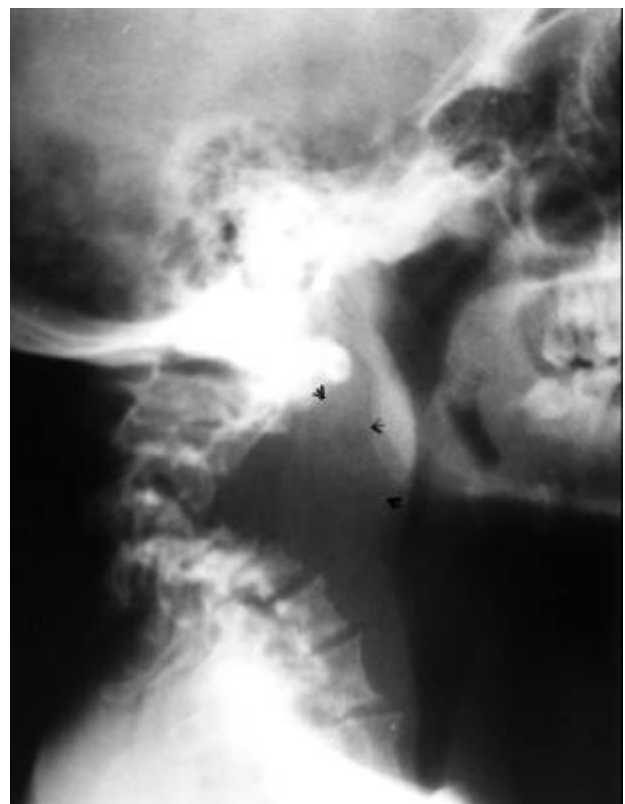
Plain radiograph of neck in lateral view showing extreme kyphosis.
